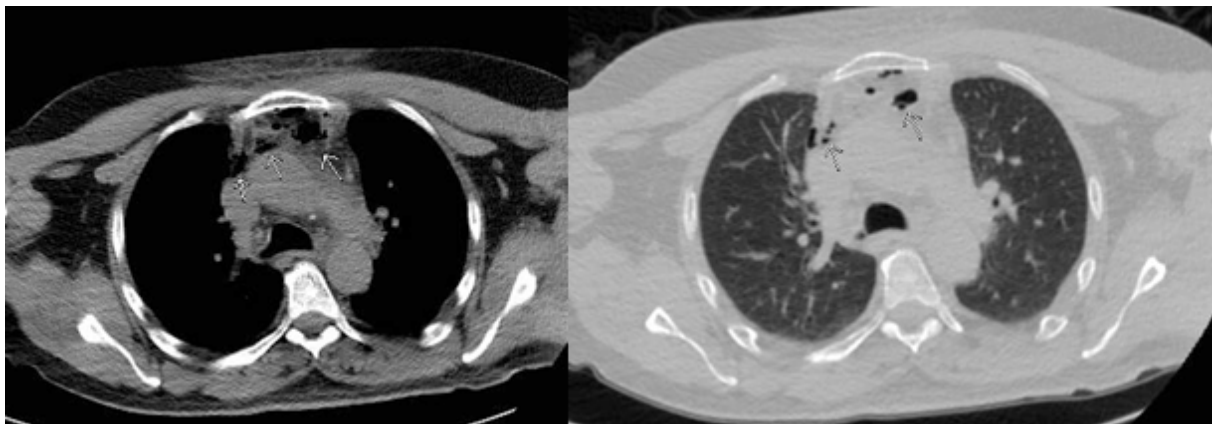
CT of the thorax.
